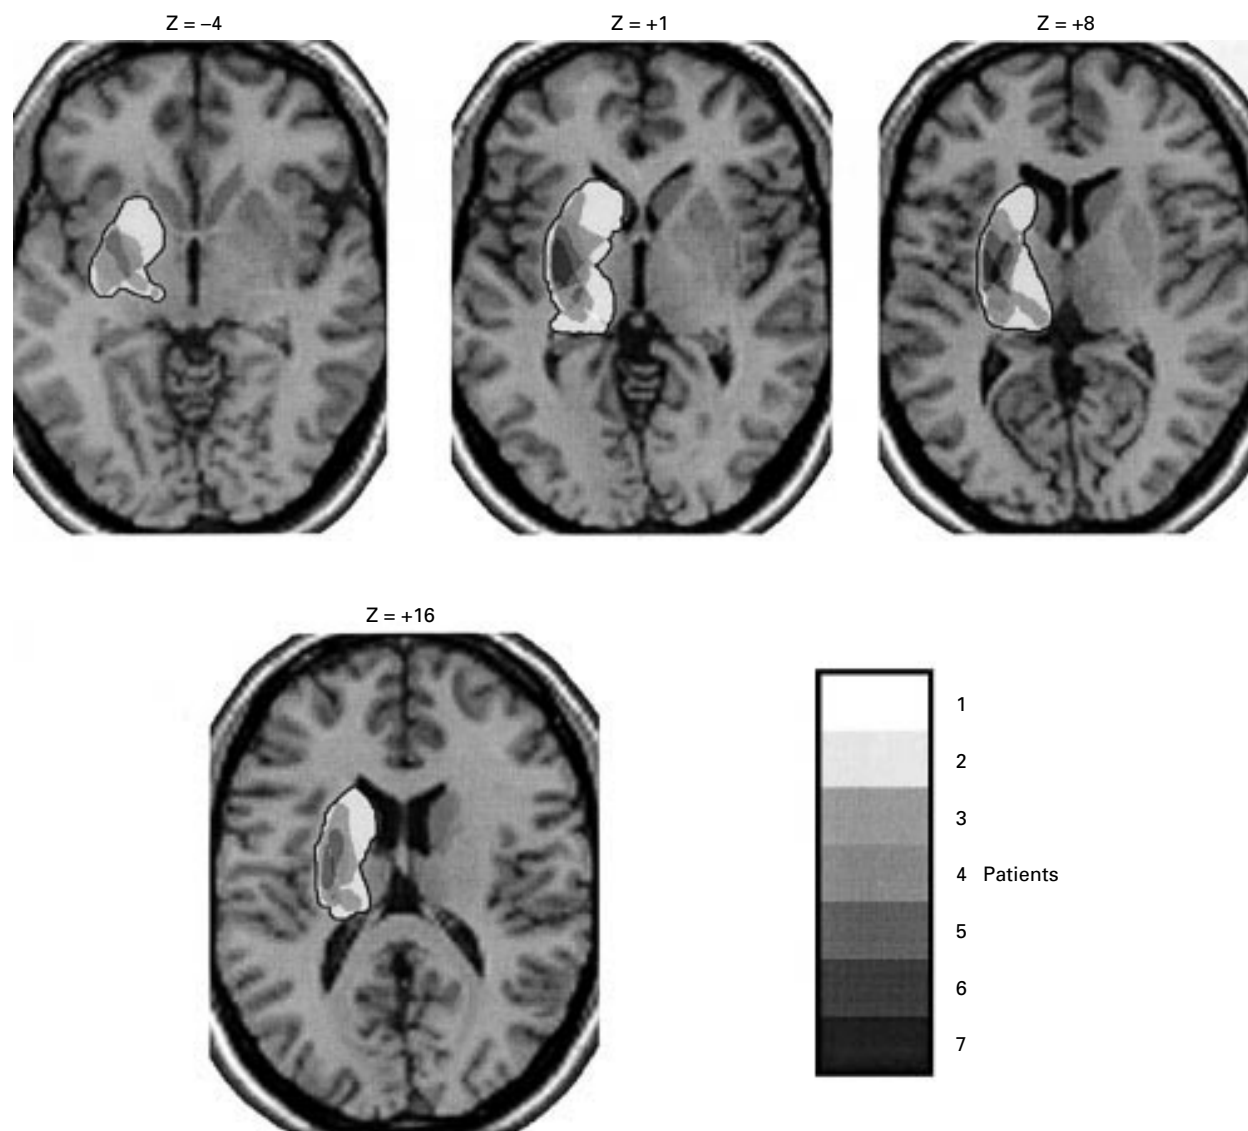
Patients with visual attentional asymmetry to the left hemifield—superposition of the individual lesions. We used a self developed computer program to transform the lesion data to Talairach normalised space and to superimpose the individual lesions on T1 weighted normalised transversal MRI (MNI template, SPM99 software package). The levels of increasing overlap were depicted in darker shades of grey. Transversal slices with the overlaid lesions were generated only at basal ganglia level (Talairach Z coordinates -4 , $+1$, $+8$, $+16$).
